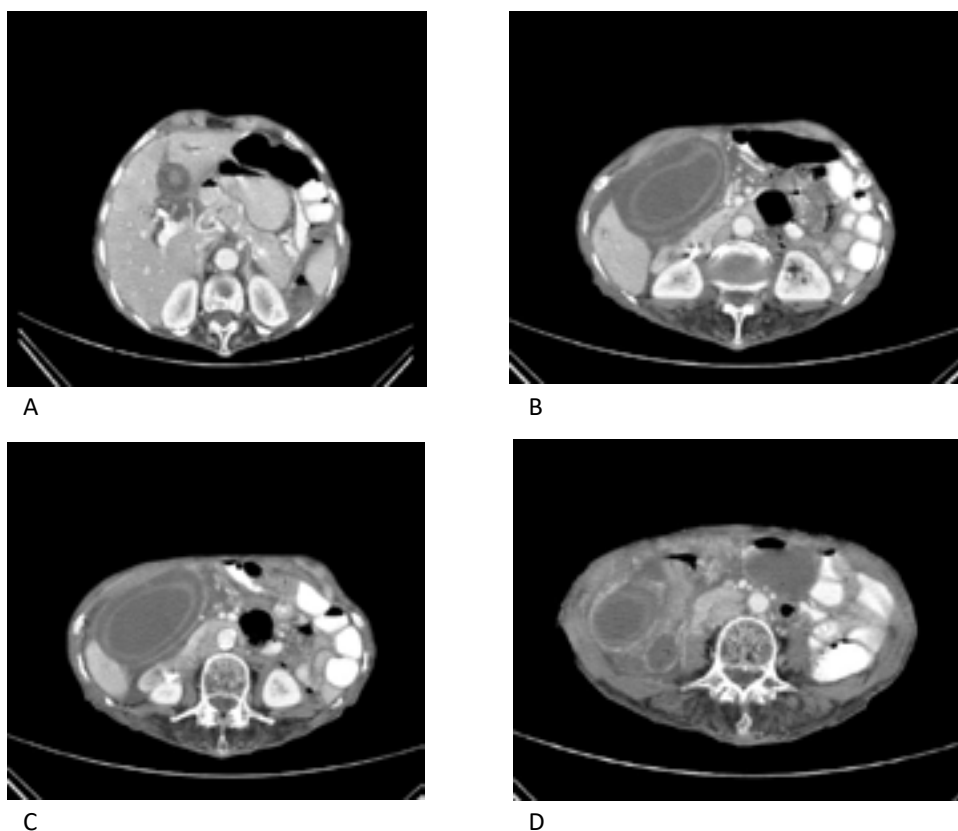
Computed Tomography Scan of the abdomen in axial section indicating a hyperdense lesion (A, B, C, D)
